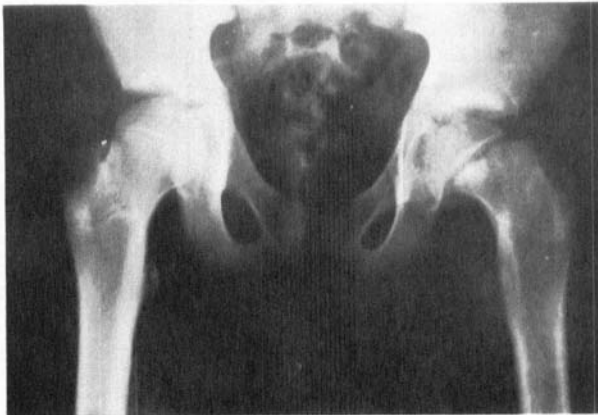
a. Roentgenological examination of both hip joints of a 12-year-old boy (No. 1), a few hours after a minor trauma to the left hip, showing pronounced slipping on that side.
